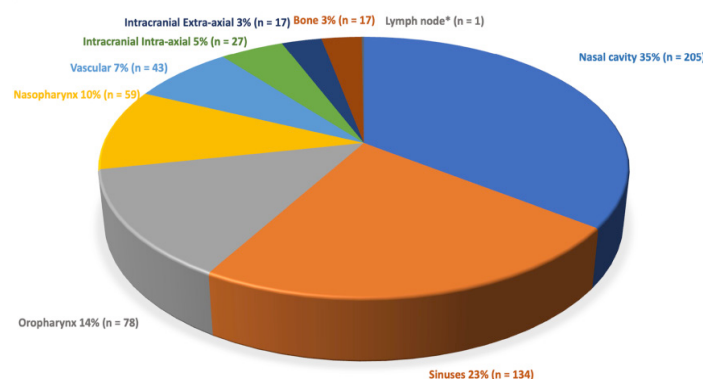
Categorical distribution of extratemporal incidental findings in temporal bone CT by location. *Indicates ratio 0.1%
